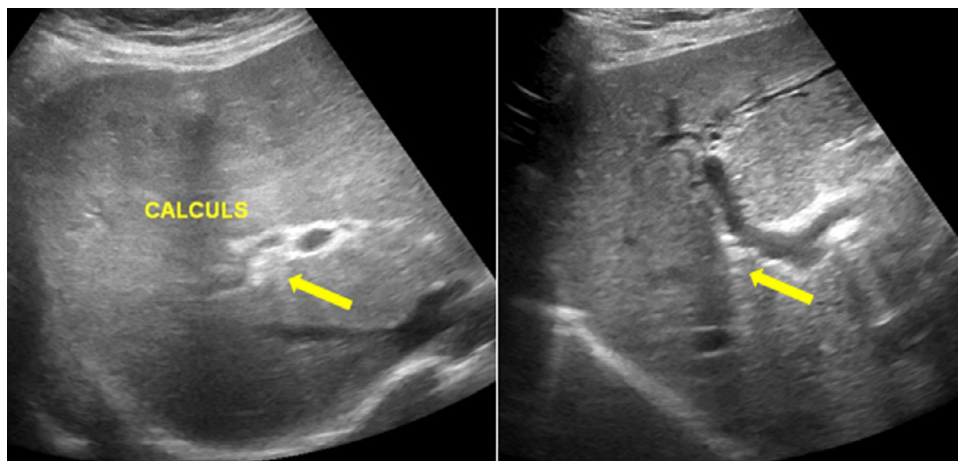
Hepatic ultrasound images in B mode showing the presence of hyperechoic intrahepatic formations, outlining the path of the intrahepatic bile ducts (IHBD), some of which describe a discrete posterior shadow cone, while others produce a comet-tail artifact testifying of their cholesterolic character.
